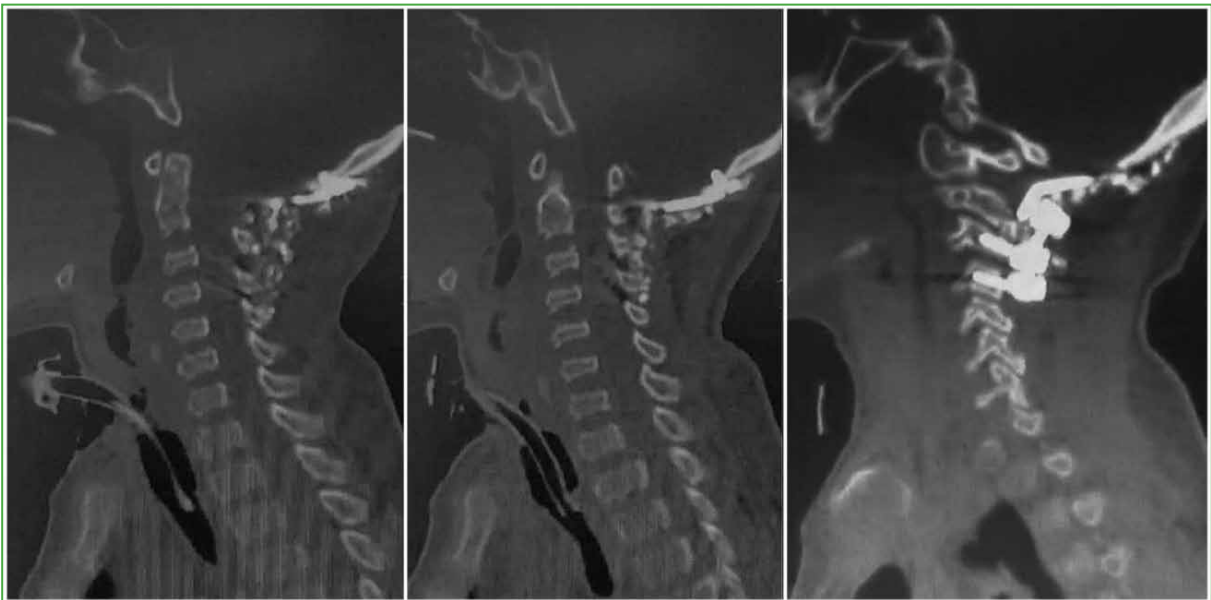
Postoperative cervical computed tomography, sagittal section. Instrumentation is appreciated, with occipital plate and cervical screws.
